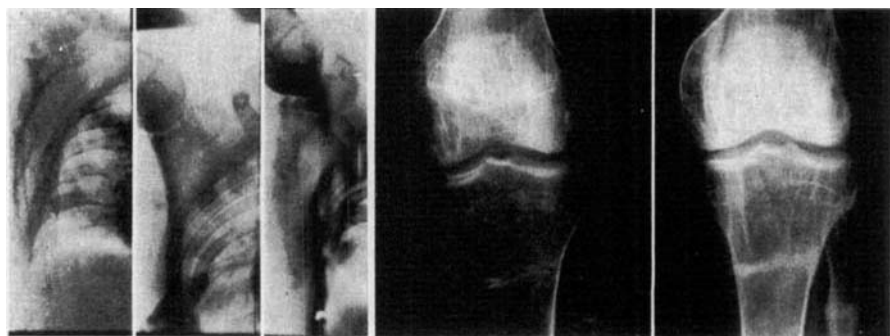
Roentgenograms showing Milkman fractures in the scapulae and in the tibia and fibula before and after metabolic treatment of the osteomalacia. After treatment the fractures are healed.
